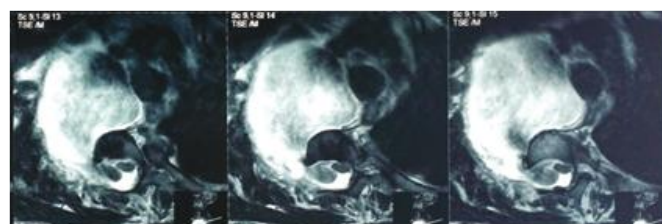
Axial T2 MRI showing CSF filled sac extending from the spinal canal into the chest cavity
